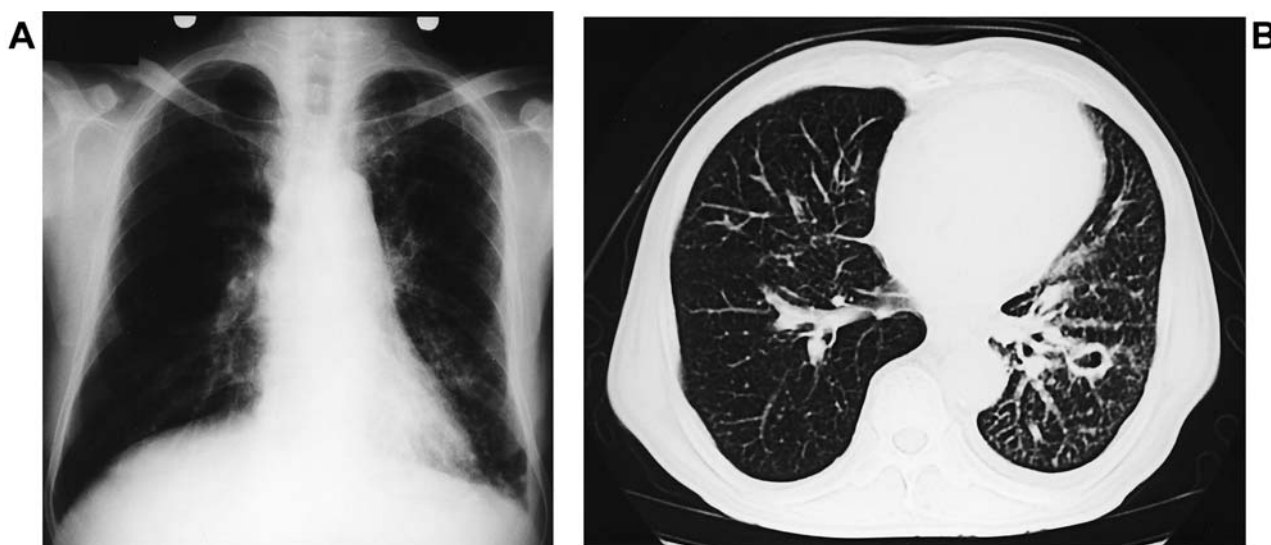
A. Chest radiograph showed reticular shadows in the left middle and lower lobes. B. Computed tomography of chest showed a cavity surrounded by multiple small nodular opacities in the left S9 and left pleural effusion.
